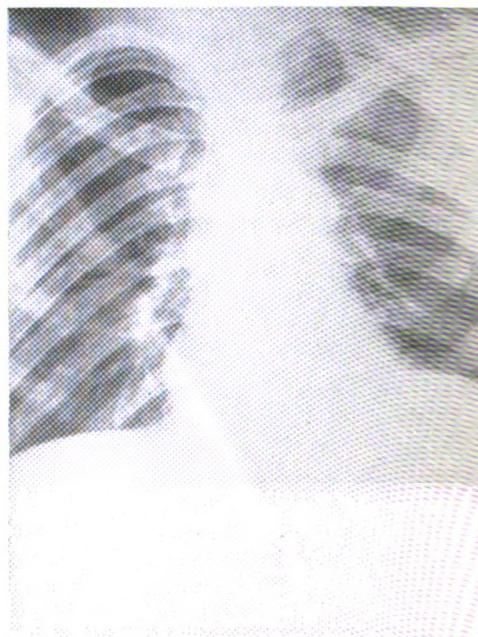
P.A. radiograph of the chest during convalescence after left upper lobectomy. The left phrenic nerve was crushed at operation
